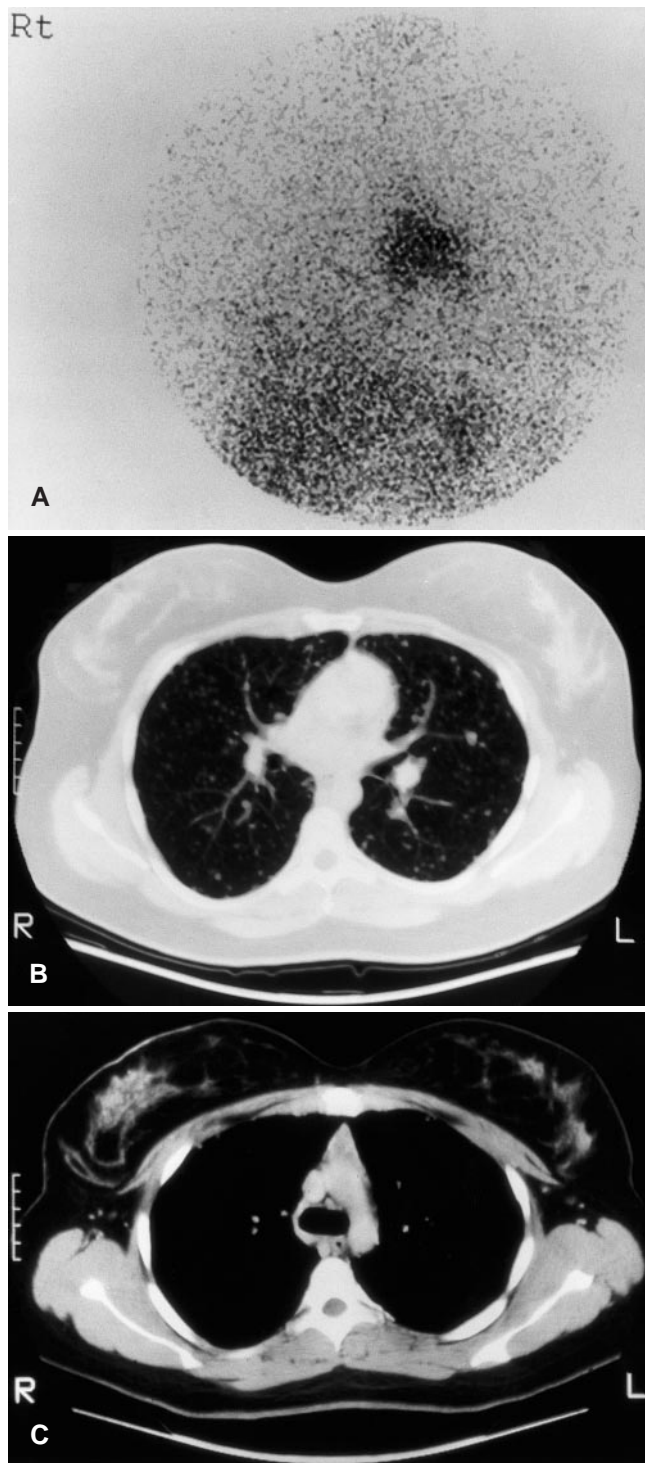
Patient 9. Diffuse uptake of radioiodine is seen in the thymus of this 27-year-old patient on the post-therapy scan following her 10th treatment (A). No uptake of radioiodine is seen within the multiple pulmonary metastases seen on CT (B). Her thymus gland had a normal appearance on CT (C)
